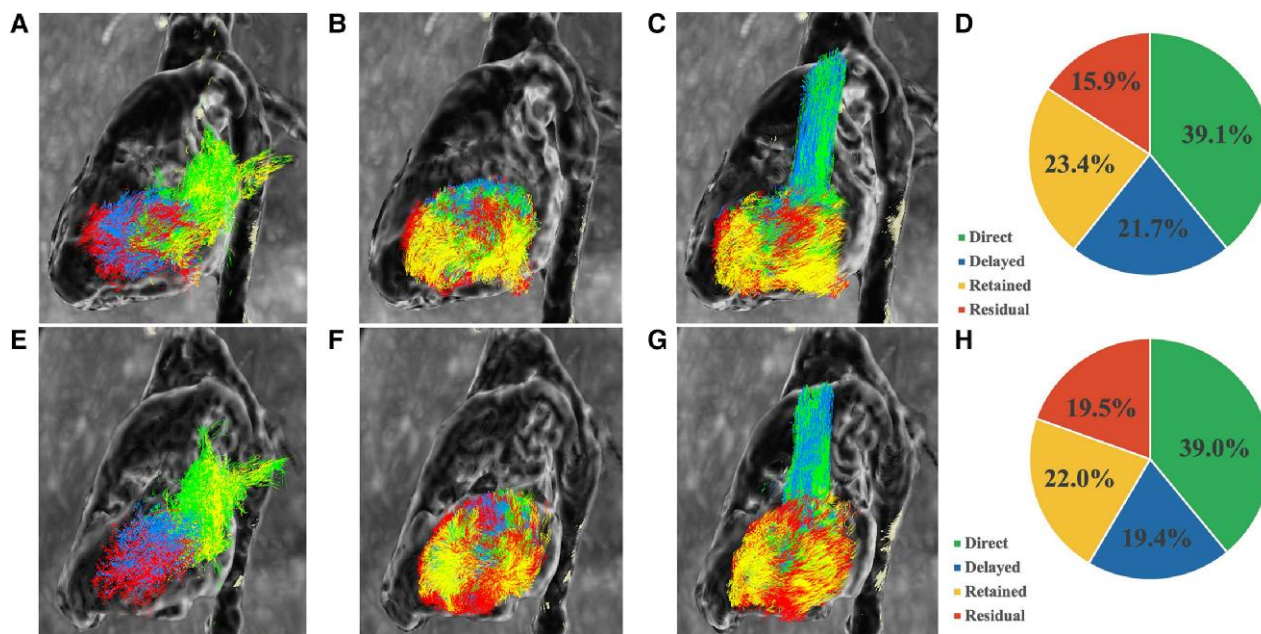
Ventricular flow analysis of four-dimensional flow magnetic resonance imaging. Before balloon angioplasty: (A) early diastolic phase, (B) end-diastolic phase, (C) peak systolic phase, and (D) percentage of the components of left ventricular flow. After balloon angioplasty: (E) early diastolic phase, (F) end-diastolic phase, (G) peak systolic phase, and (H) percentage of the components of left ventricular flow.
